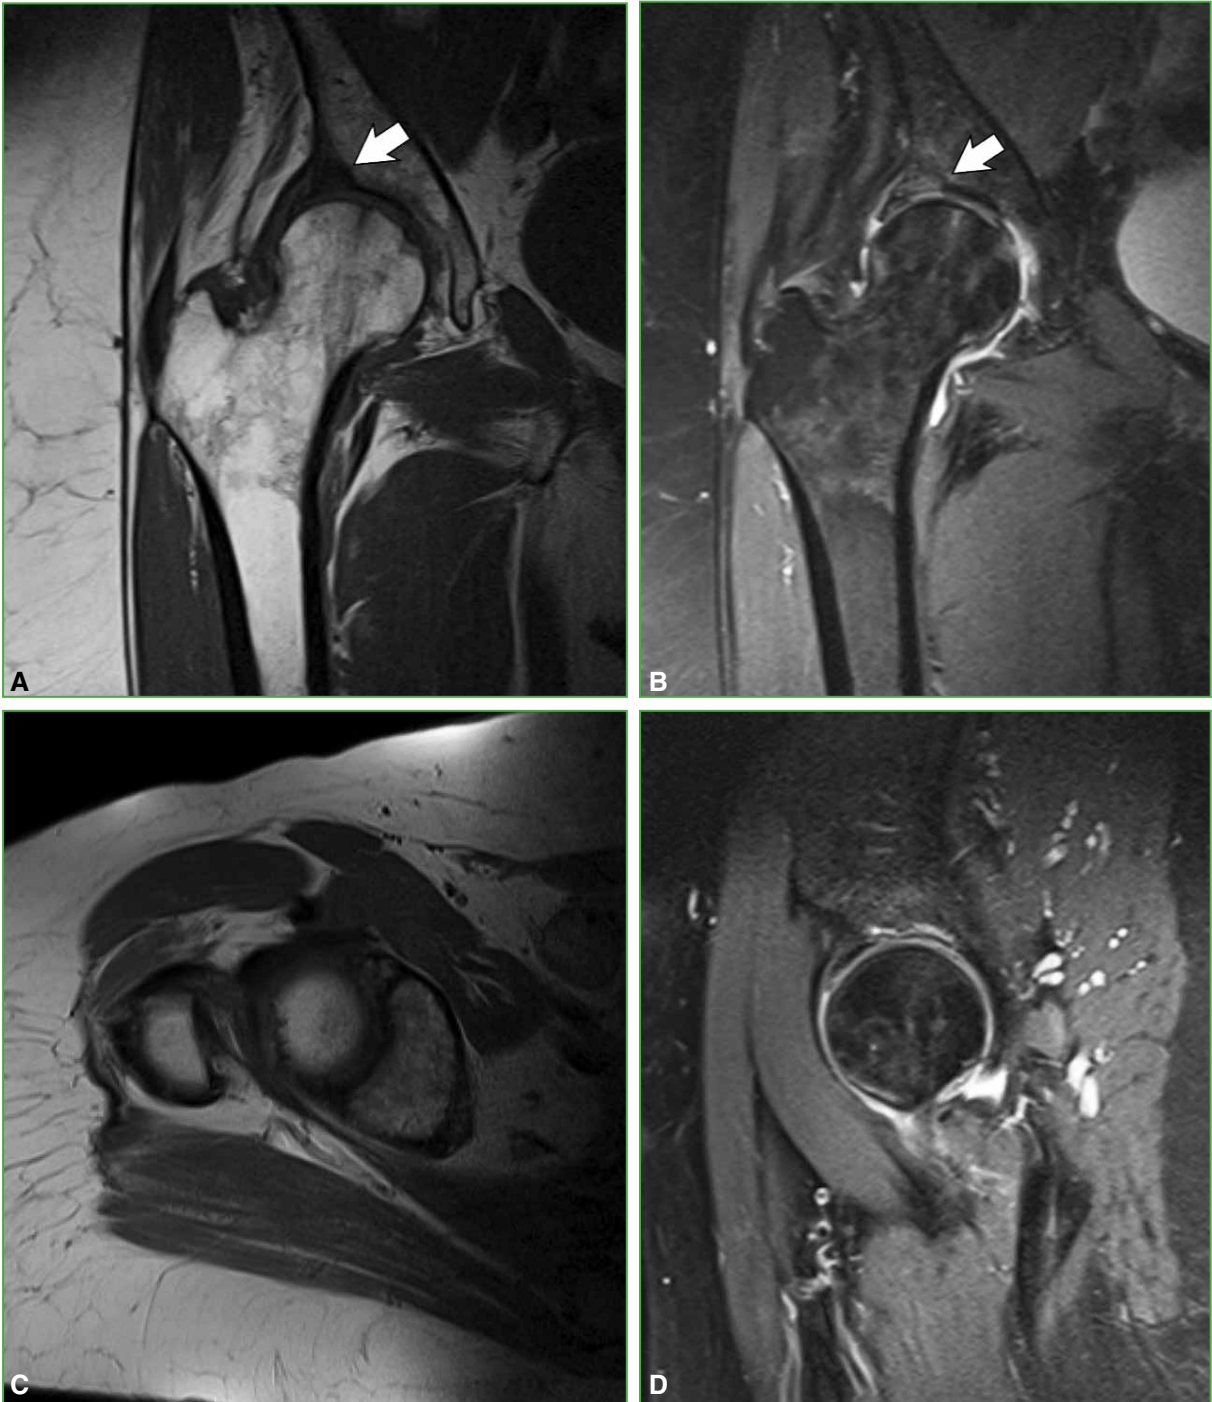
Magnetic resonance imaging, coronal planes (A and B), axial plane (C), sagittal plane (D). Hypointense signal in T1-weighted sequence and hyperintense signal in T2-weighted sequence. Periacetabular edema suggestive of insufficiency fracture.
